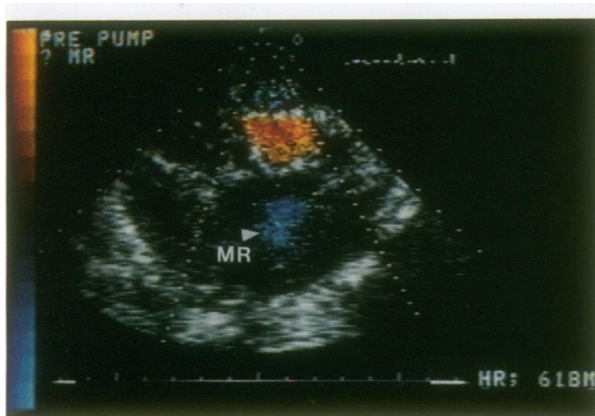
Short-axis parasternal-equivalent view of left atrium just behind the mitral valve, demonstrating central blue jet of regurgitation. Antegrade systolic flow through the aortic valve is seen at top of image.
